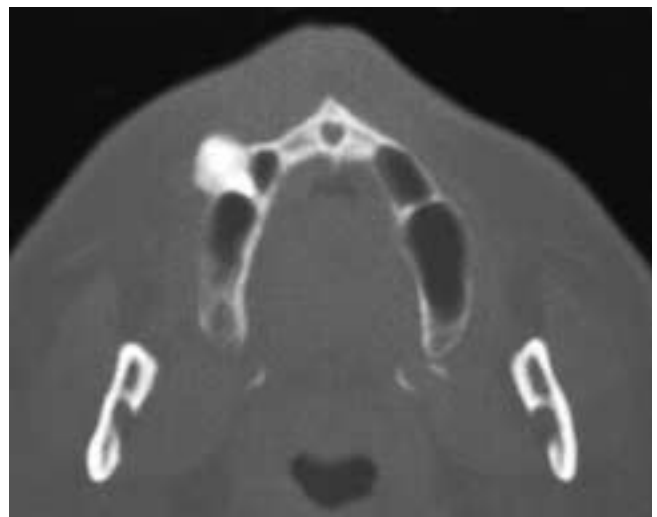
Axial CT scan shows a dense osseous mass arising in the right maxillary alveolus. The lesion is localized to one area, and the remaining alveolus is normal. This patient had a cementoma.
